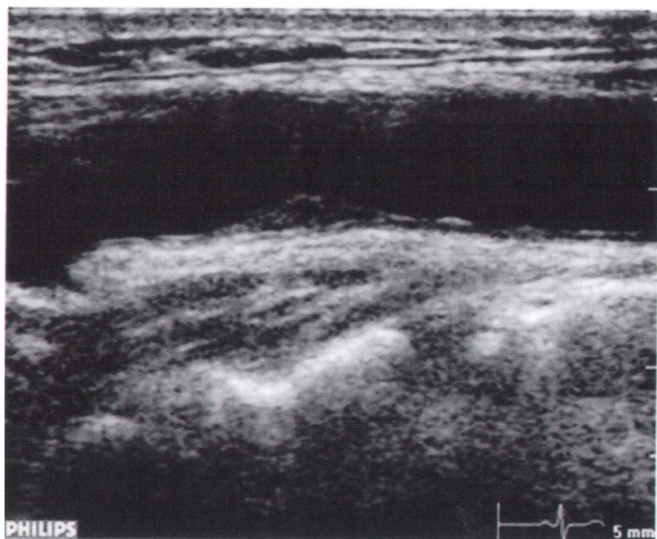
A variable quality slice-encoding example. In this example, we show the captured carotid plaque ultrasound video frame, with quantization parameters (QPs) of 38/30/28. Diagnostically, the focus was on the reliable encoding of the plaque. The plaque region was encoded using $QP = 28$ as in Figure 3b (example based on [8]).
